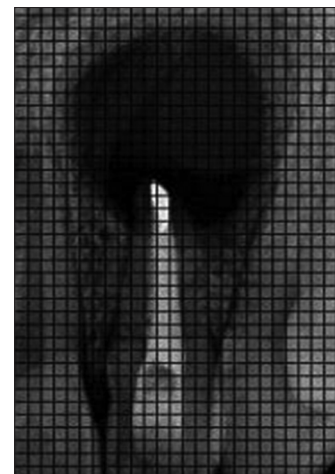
Procedure for measuring size of peri-apical lesion on Digital intra-oral peri-apical (IOPA) radiographs with the help of grids.
